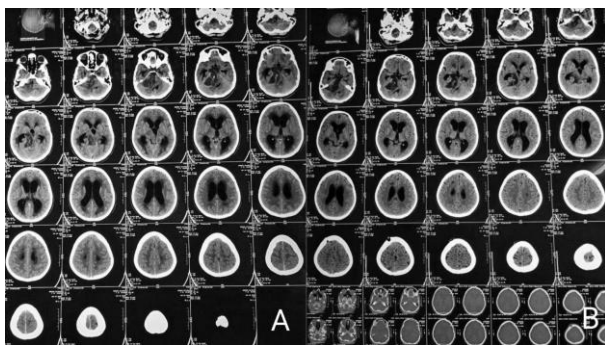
A: Preoperative CT Brain Plain of an 11-year-old boy with Hydrocephalus secondary to Posterior Fossa Tumor. B: Postoperative CT Brain Plain following ETV.
